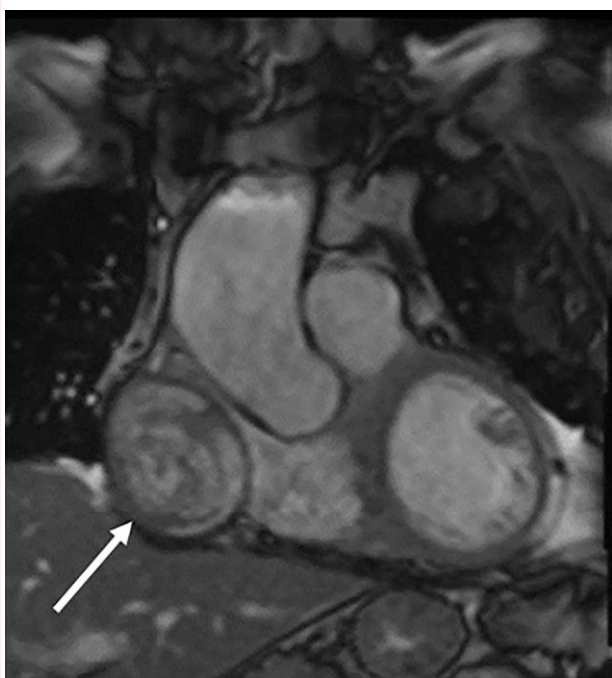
Cardiac magnetic resonance imaging demonstrating large partially thrombosed saphenous vein graft aneurysm to the right coronary artery (white arrow).
